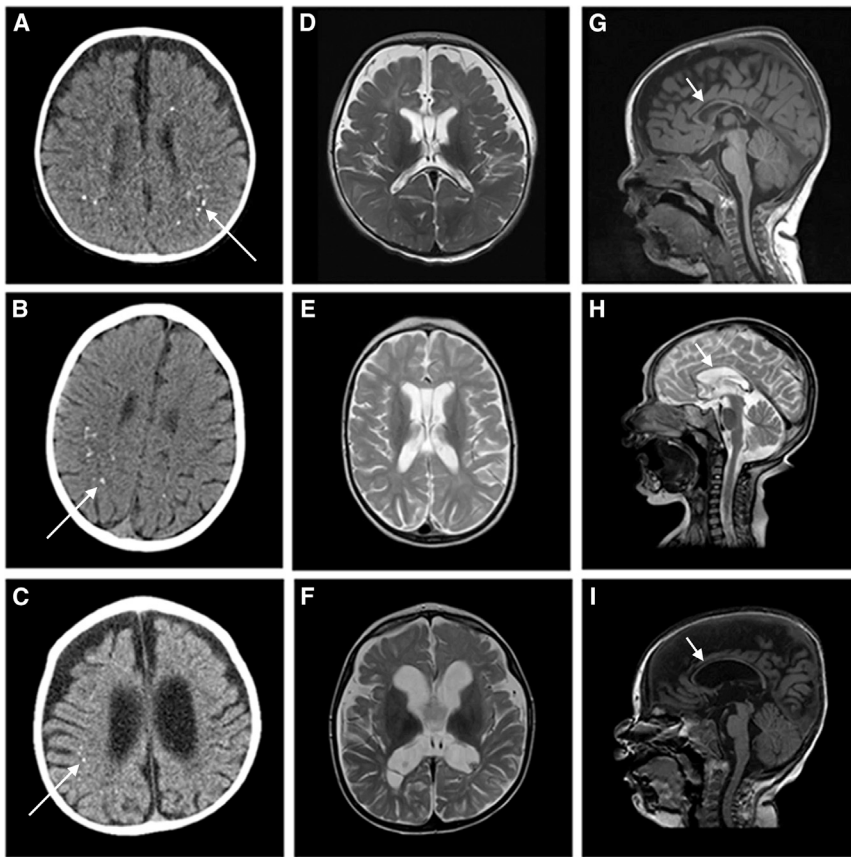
Brain MRI and CT for Affected Individuals with Bi-allelic *NRROS* Variants (A, B, and C) Computed tomography (CT) brain imaging shows punctate calcification in subcortical and periventricular white matter (long arrow). (D, E, and F) T2-weighted axial magnetic resonance imaging (MRI) brain imaging shows increased extra-axial spaces, reduced white matter volume, and delayed myelination. (G, H, and I) Sagittal MRI brain imaging shows diffusely thin corpus callosum (short arrow). Brain imaging of affected Individual II:4 in Family 1 (A, D, G) at age nine months; affected Individual II:3 in Family 3 (B, E, H) at ages 18 months (CT) and 19 months (MRI); and affected Individual II:2 in Family 4 (C, F, I) at age 16 months.
